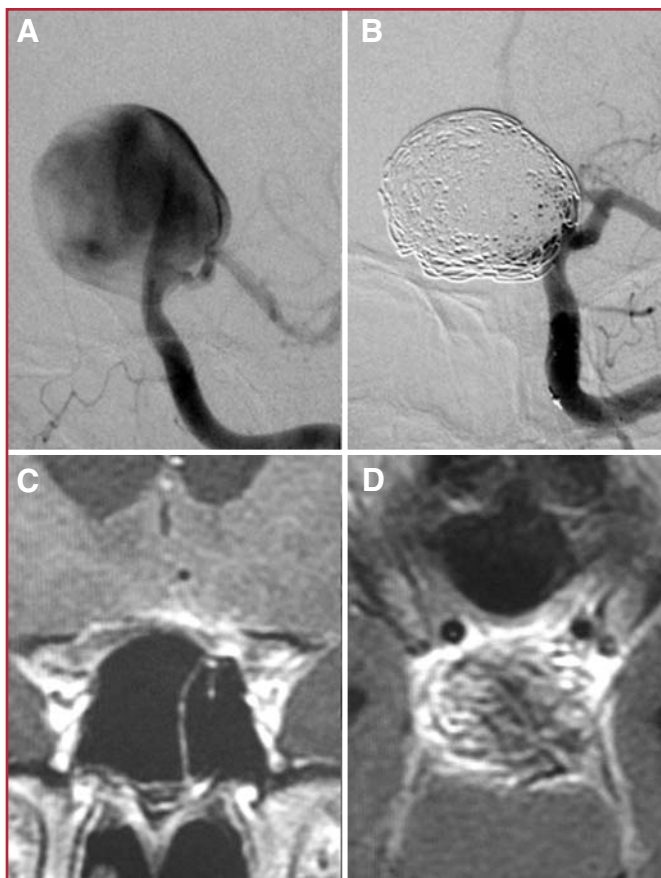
A and B, pre- (A) and postoperative (B) left internal carotid artery angiograms showing near-complete coil embolization of the giant aneurysm. C and D, magnetic resonance images. Postembolization coronal (C) and axial (D) T1-weighted images with gadolinium showing intense perianeurysmal enhancement with compression on the optic chiasm.
